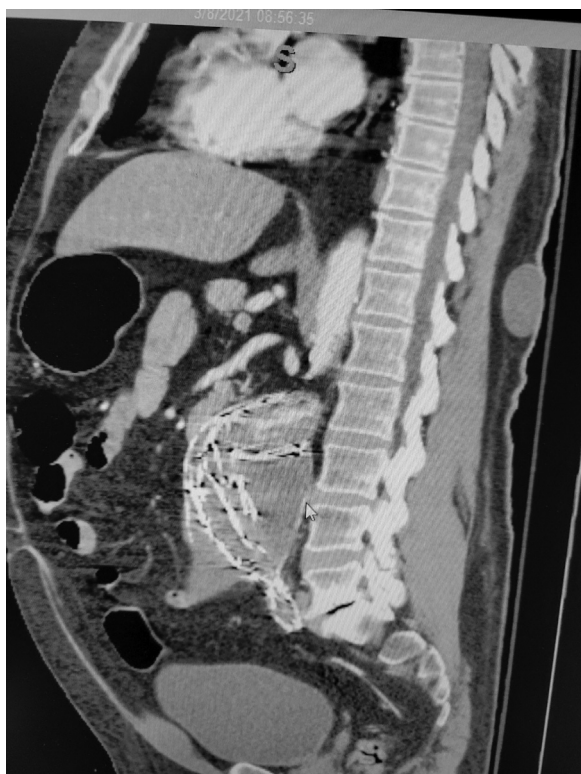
Sagittal section of a computed tomography angiogram showing a kinked, occluded, and thrombosed Endologix aortic stent graft with a sacular abdominal aneurysm measuring 6.0 × 5.1 × 4.4 cm.
